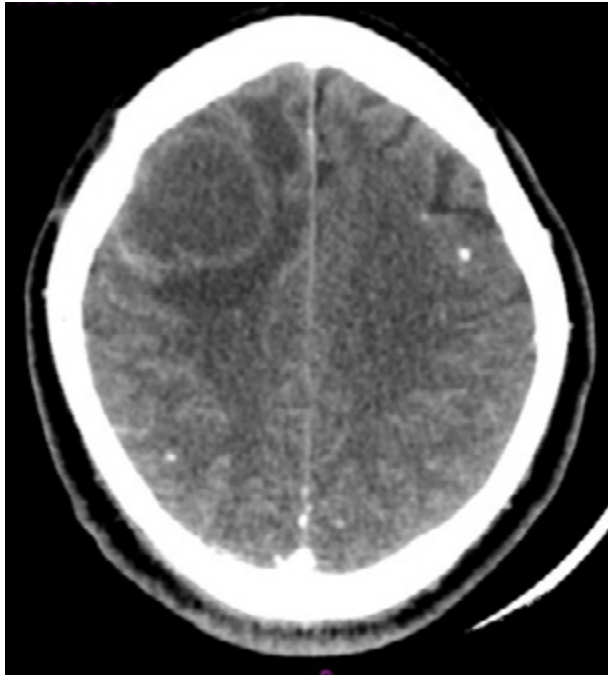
Computed tomography with right frontal subcortical cystic lesion, perilesional edema and calcified nodules.
